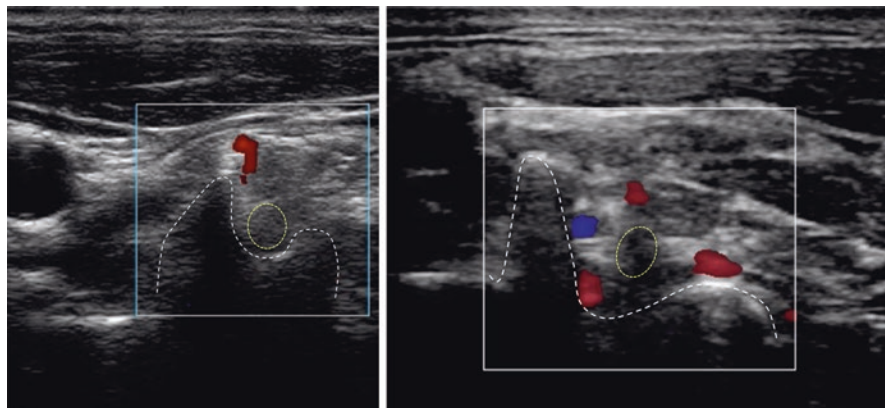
The left sonogram showed the typical location of the vessel in the ventral aspect of the C6 nerve root. The right sonogram showed the rich presence of the vessel in both the ventral and dorsal aspect of the nerve root. (Reprinted with permission from Philip Peng Education Series)
